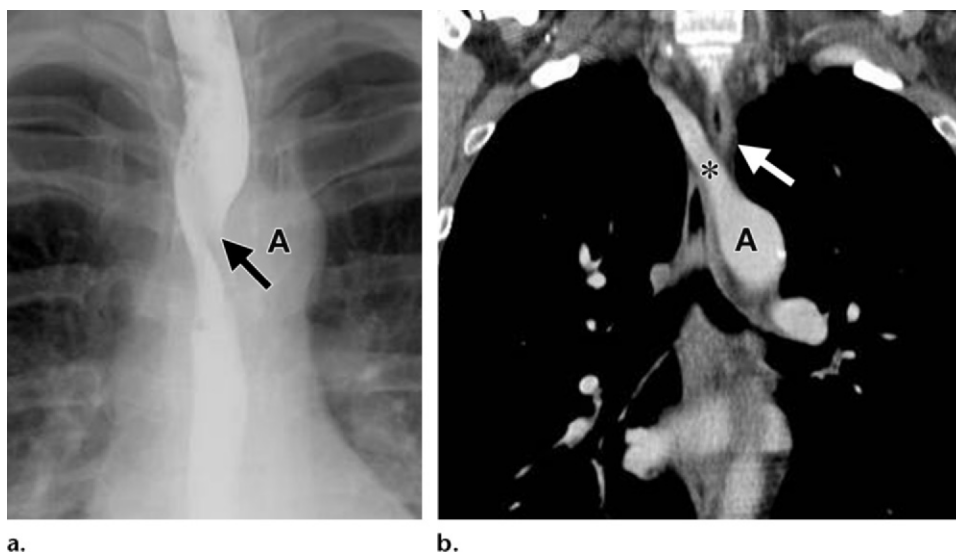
Aberrant right subclavian artery. (a) Single-contrast anteroposterior image shows obliquely oriented mass effect on the thoracic esophagus (arrow) just at and above a left-sided aortic arch (A). Mass effect was noted posteriorly in the lateral projection. (b) Contrast-enhanced CT image shows an aberrant right subclavian artery (*) arising from the left-sided aortic arch (A) and crossing the esophagus (arrow) as it extends obliquely to the right.
